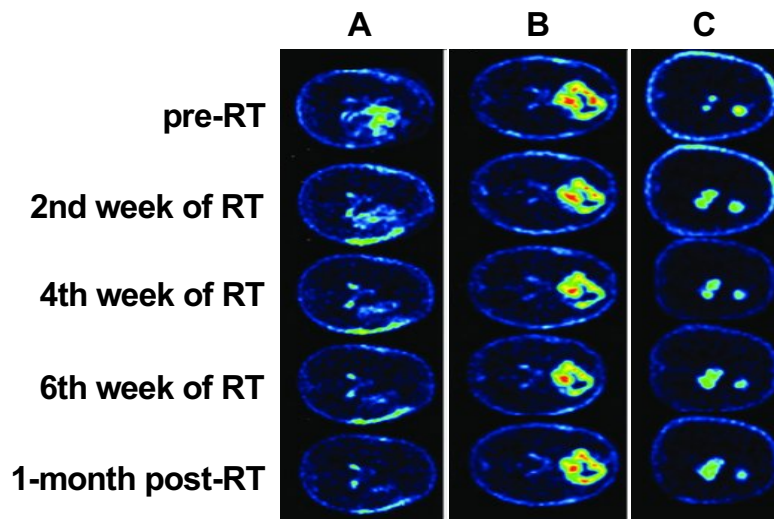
Figure i2. 18 F-Fluoromethylcholine positron emission tomography magnetic resonance imaging (MRI) in 3 glioblastoma patients. (A) Patient with GBM in the right frontal and temporal lobes; the patient is classified as a partial responder by the Response Assessment in Neuro-Oncology (RANO) criteria. (B) Patient with a bifrontal GBM; the patient was classified as stable disease using the RANO criteria. (C) Patient with multifocal GBM; a new lesion was discovered on a follow-up MRI, indicating that the patient's disease was progressing (adapted from Bolcaen *et al.*, 2017).
